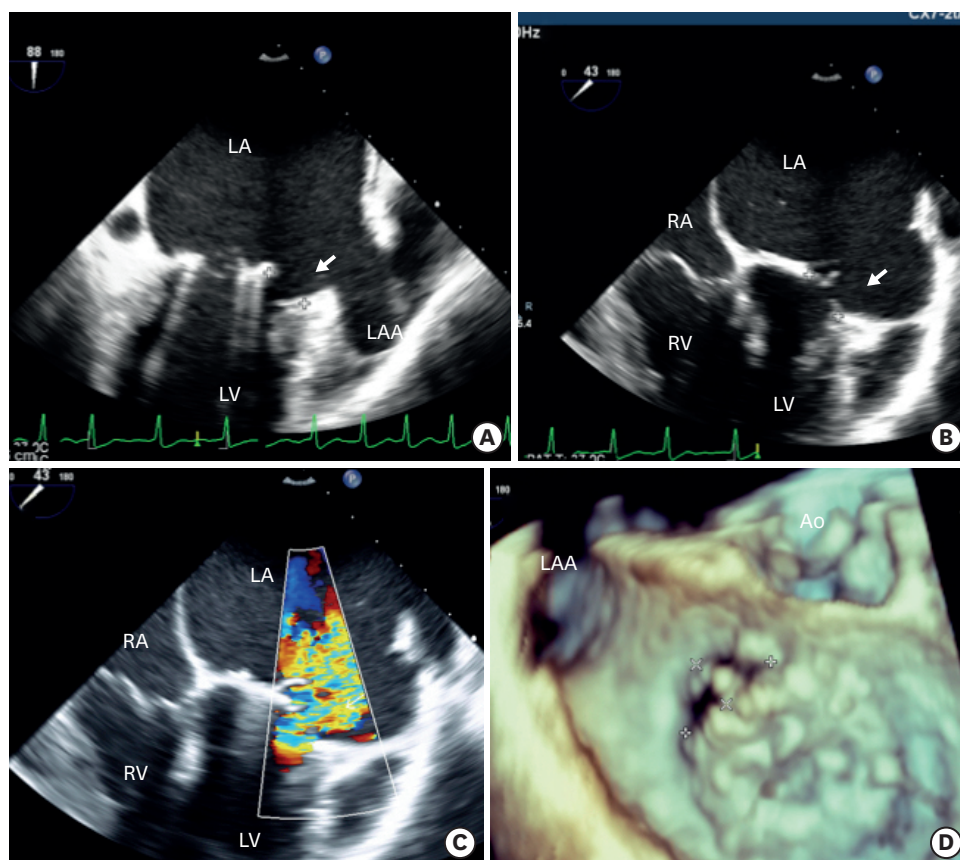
Two chamber (A) and 4 chamber (B) views on transesophageal echocardiogram with colour flow mapping (C) show large anterolateral mitral paravalvular leak (arrow) adjacent to LAA (Movie 1). Enface left atrial view on 3-dimensional echocardiogram (D) shows the orientation of the leak in surgical view.
